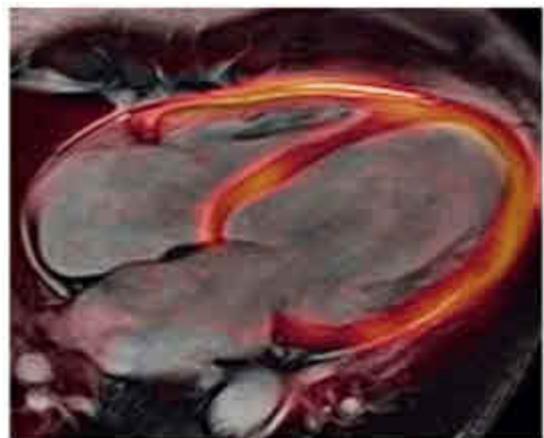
Cardiac imaging, mMR technology eliminates motion effects and PET image degradation, whilst gating and triggering tools deliver excellent MRI images (courtesy Siemens Healthcare)
